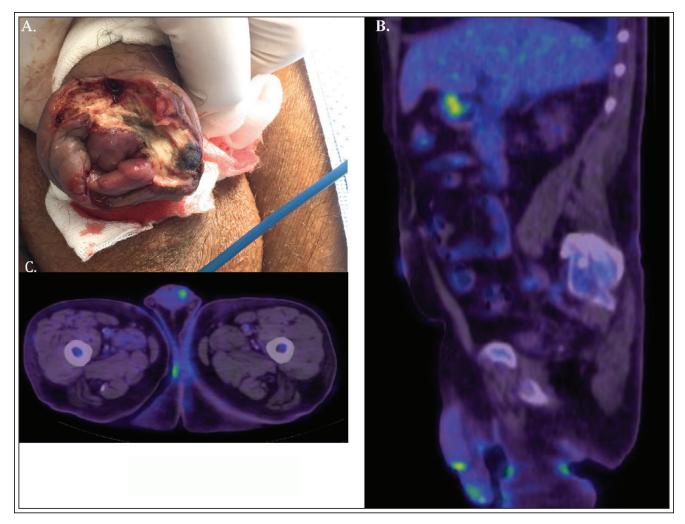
Mycosis fungoides of the penis. A) Intraoperative photo depicting the necrotic MF lesion extending from the foreskin to the glans penis measuring 14 mm x 12 mm x 8 mm. PET/CT demonstrating increased 18F-fluorodeoxyglucose (18F-FDG) avidity in the penis in sagittal B) and axial C) windows.
